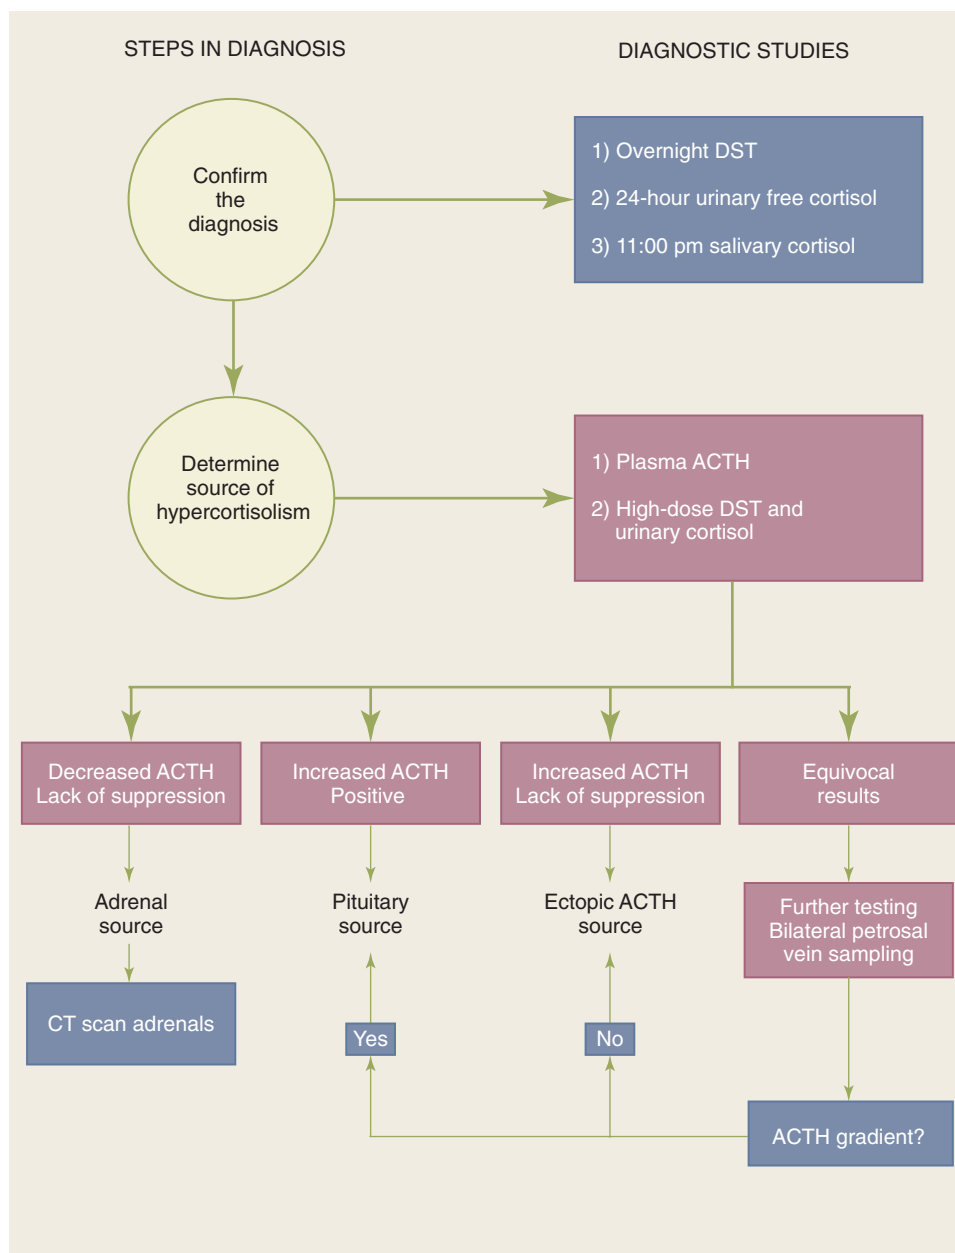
Diagnosis of Cushing's syndrome. ACTH = adrenocorticotrophic hormone; CT = computed tomography; DST = dexamethasone suppression test.
